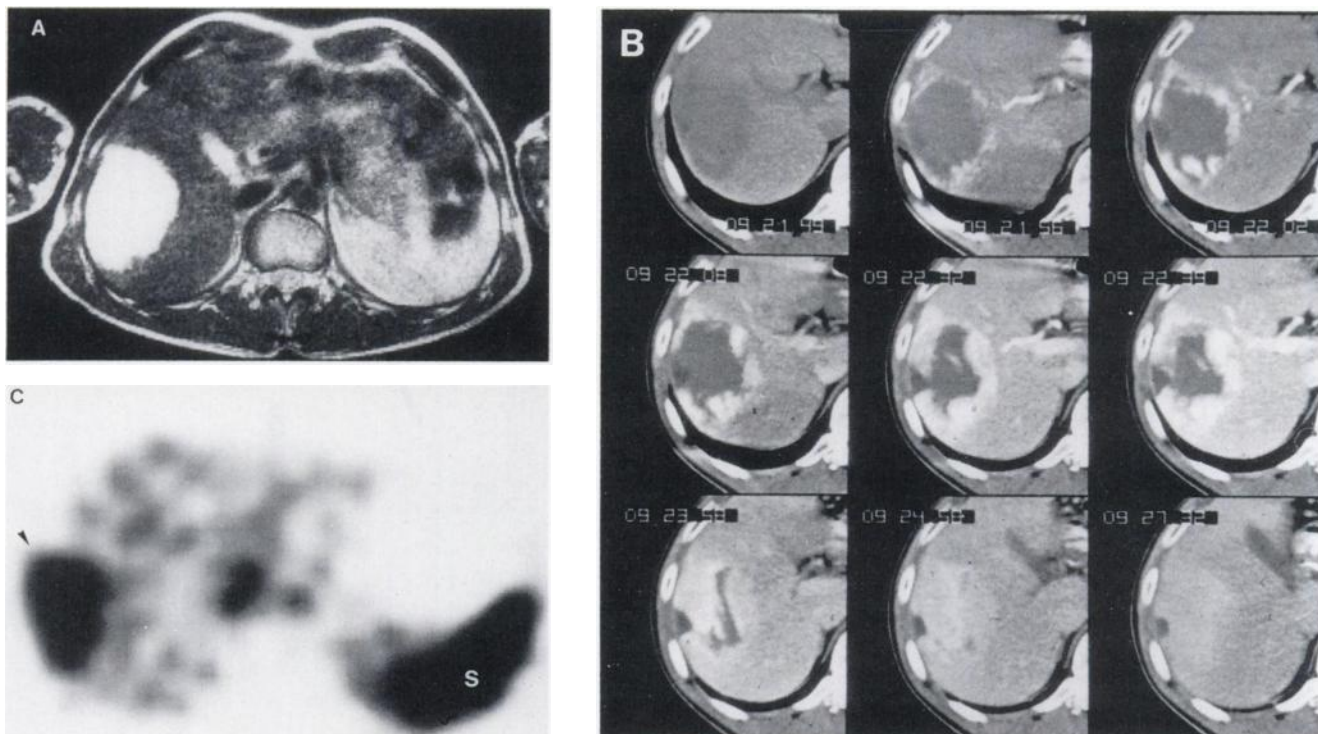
Typical appearance of hemangioma in MRI, CT and ^{99m}Tc -RBC SPECT. (A) Transverse T2-weighted image shows a large lesion with increased signal intensity in the right lobe of the liver. (B) Sequential CT images at the same level demonstrate characteristic appearance with early peripheral enhancement followed by filling in of the central part. (C) Transverse slice of RBC SPECT shows a large area with increased activity uptake (arrowhead). The spleen (S) is depicted.
